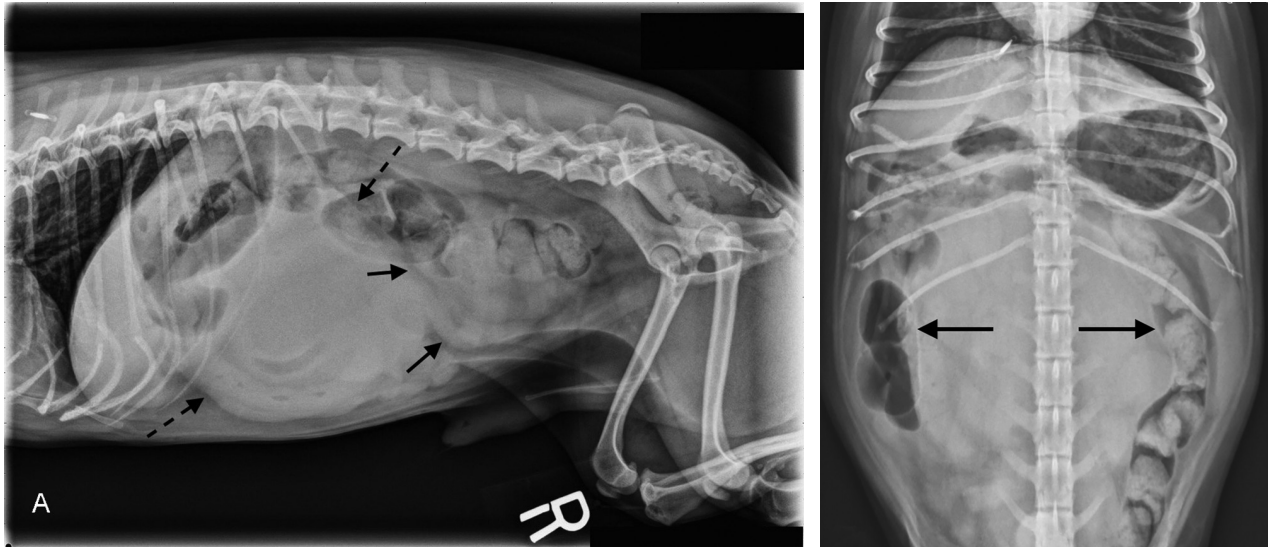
Same radiographic images as in Figure 1. A—There is a large, round mass of soft-tissue opacity in the cranial to middle portion of the abdomen (dashed arrows) causing craniodorsal displacement of the stomach. Notice the apparently normal margins of the urinary bladder (arrows). B—The soft tissue mass effect seen in the cranial to middle portion of the abdomen causes lateral displacement of the small intestines and colon (arrows).
